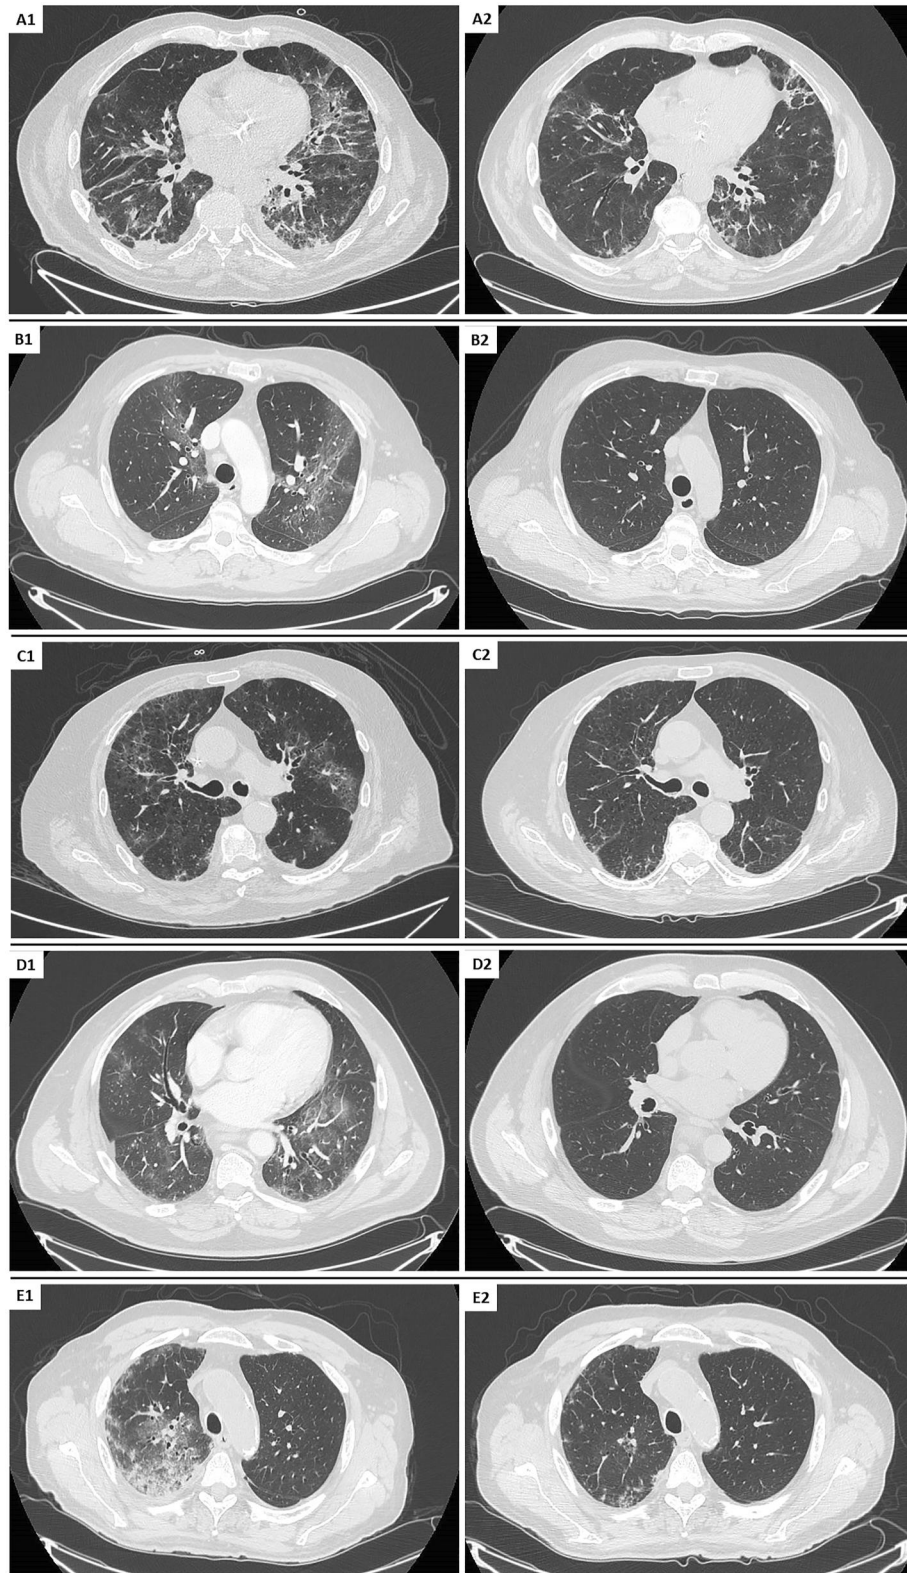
Lung computed tomography scan (CTS) features before and after dual antivirals treatment with remdesivir + nirmatrelvir/ritonavir of the five patients who underwent radiological follow-up. (A) (1–2) correspond to patient 8, (B) (1–2) correspond to patient 4, (C) (1–2) correspond to patient 5, (D) (1–2) correspond to patient 2, (E) (1–2) correspond to patient 7.
